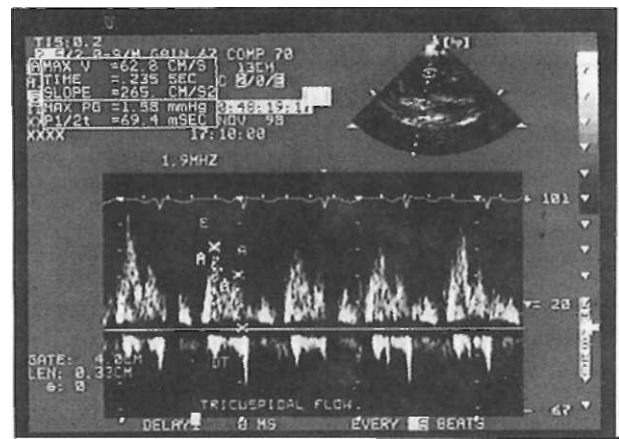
The tricuspid flow from the parasternal short axis echocardiographic view. (E: Early diastolic filling of the right ventricle, A: Atrial contraction, DT: Deceleration time of the right ventricle)
